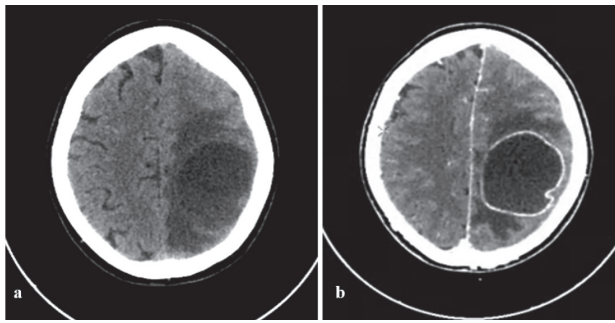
Axial CT pre (a) and post (b) intravenous contrast
